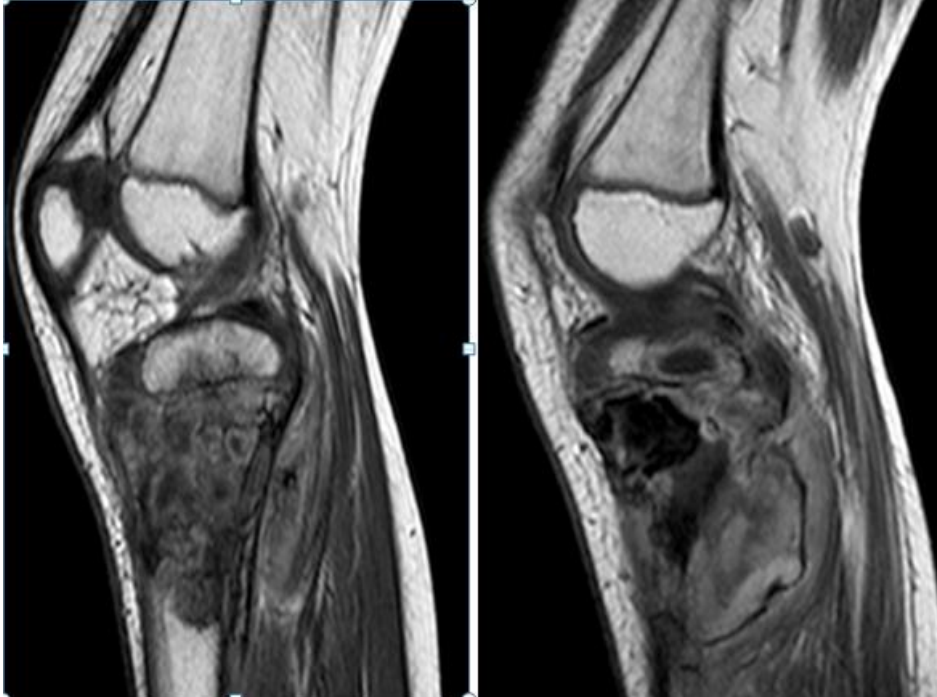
Sagittal section, T1-weighted sequence: metaphyseal process of the upper end of the right tibia with heterogeneous signal, pushing back the soft parts of the posterior muscle compartment of the leg.
